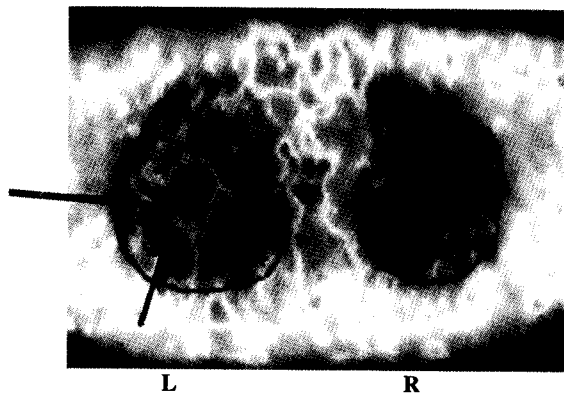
^{18}F FDG PET after injecting allergen in the left upper lung field in a case with asthma under bronchoscopy. Injected site is well shown as a hot area (as showed by arrows).
